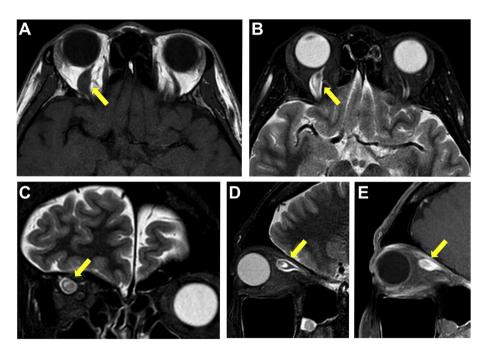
Magnetic resonance imaging of the right orbit before treatment.
